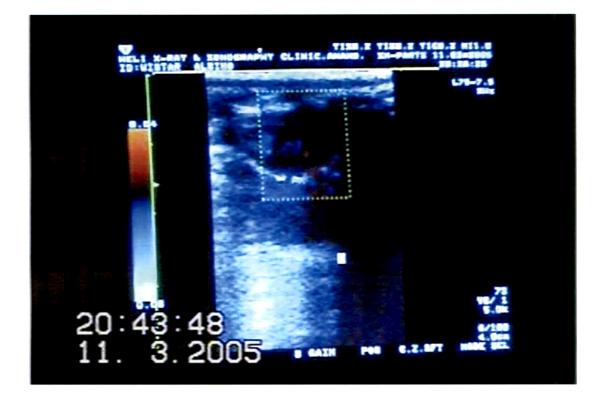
A Caridac image showing doppler signals received (red color)in conventional imaging (Color Doppler) after administration of liposomes
